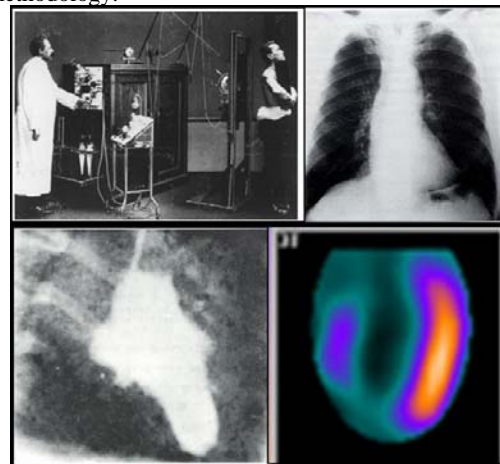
Primitive chest x-ray system and examples of x-ray, fluoroscopy and nuclear imaging.
